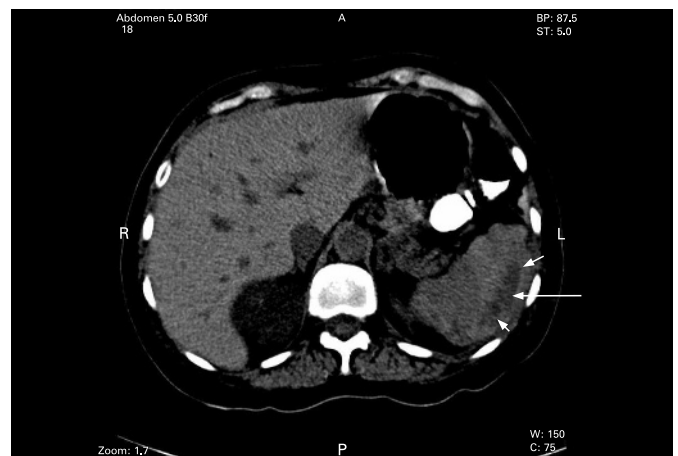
Abdominal CT scan showing a large subcapsular splenic haematoma (arrows).
